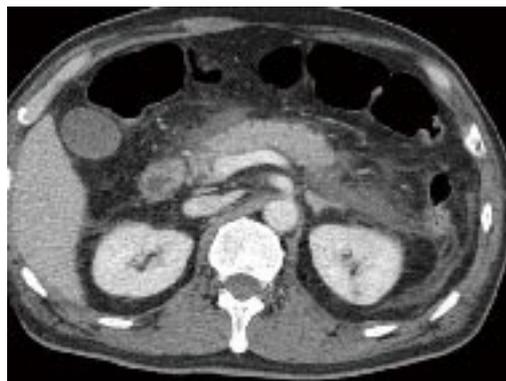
Abdominal CT showed inflammation and swelling of the pancreas, and a blurring of the fat planes in both the peripancreas and the left anterior pararenal space.
